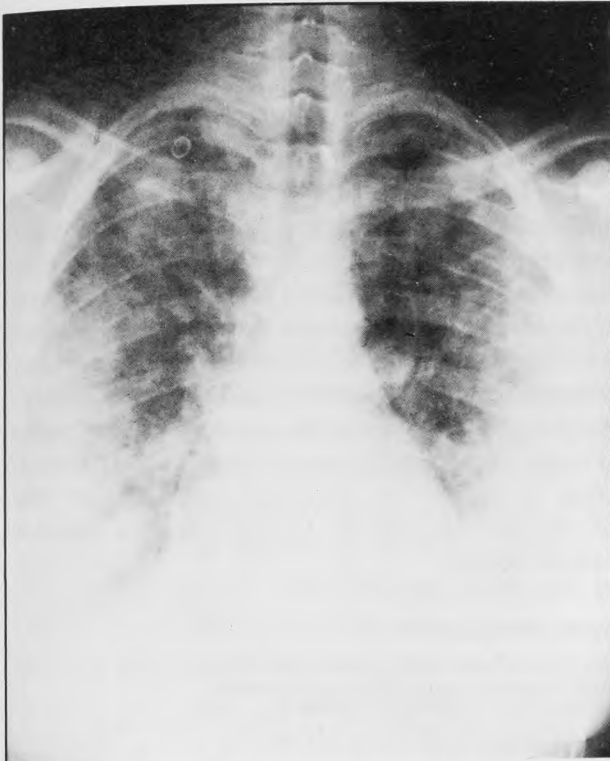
Repeat chest x-ray film 12 days later revealing bilateral diffuse patchy alveolar infiltrates
